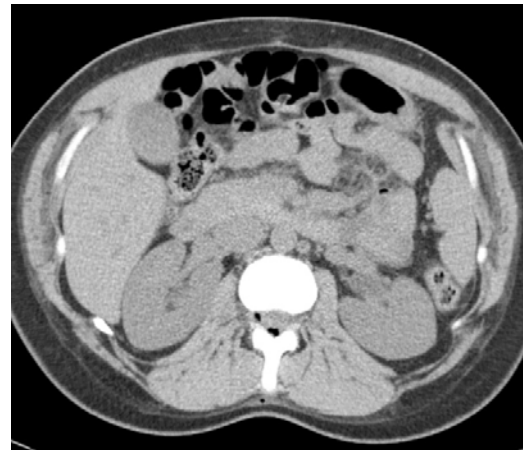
Axial non-contrast CT shows extradural intra-spinal air at one level. Subcutaneous focus of air is visualized in tract from the epidural injection.
